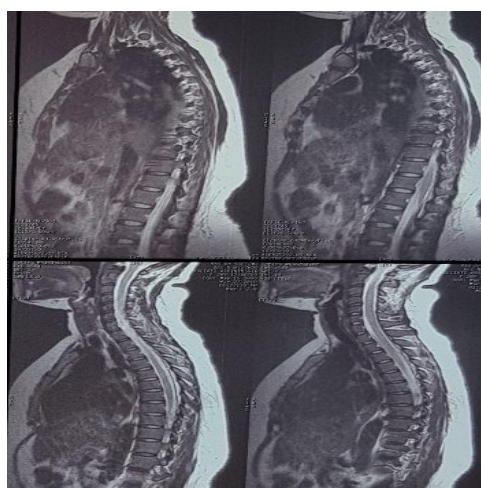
Normal contrast-enhanced cervicothoracic spine MRI
